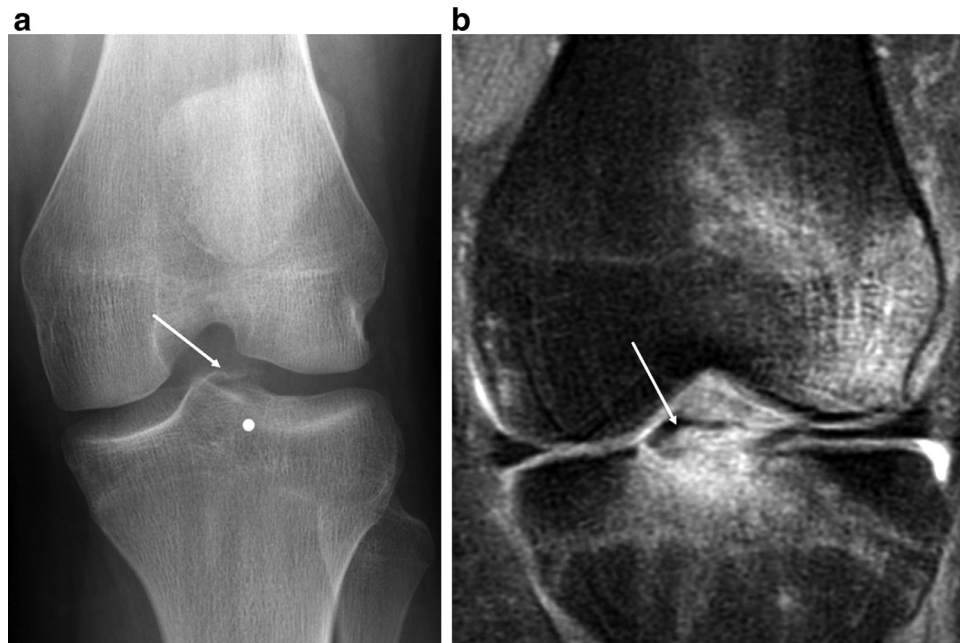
Radiographic and MR imaging of the left knee in a 16-year-old boy presenting with pain after football injury. Anteroposterior radiograph (a) demonstrates an avulsion fracture (arrow) at the ACL attachment at the tibial spine (metallic BB marker placed over site of pain by radiographer). Coronal T2-weighted fat saturated (b) MR image confirms the tibial spine avulsion (arrow) with underlying marrow edema.
